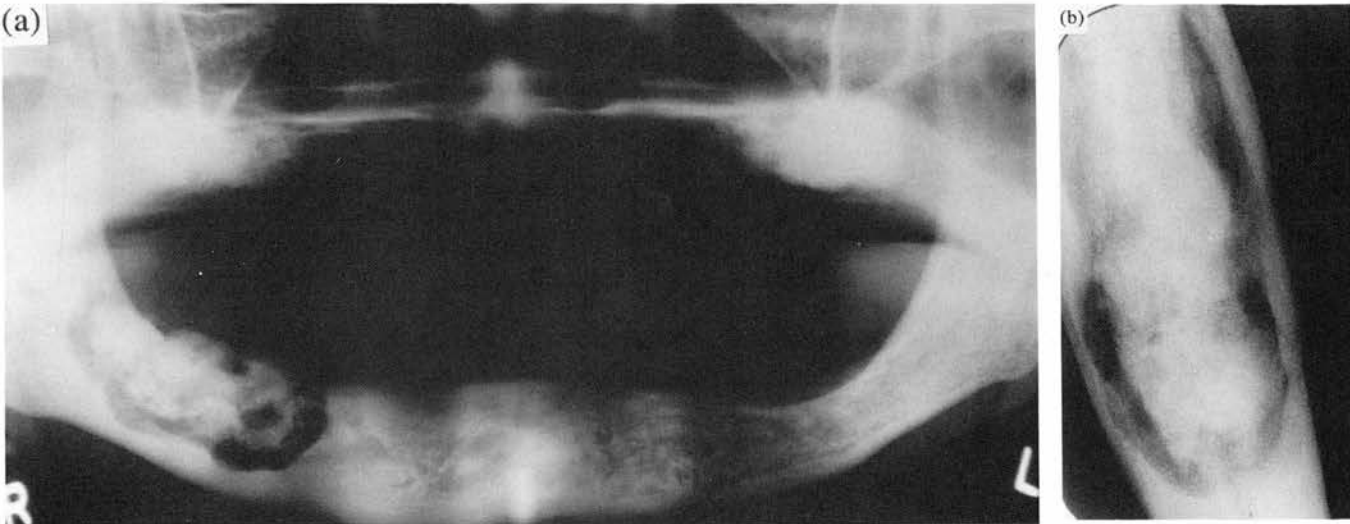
(a) A panoramic radiograph (case 3) showing FOD involving both upper molar areas and the lower right molar-premolar area. The latter area exhibits a wide translucent zone between the opacity and the adjacent bone. (b) No significant expansion is evident on the true occlusal view of the lesion in the lower right quadrant: the wide translucent zone is again clearly demonstrated.
